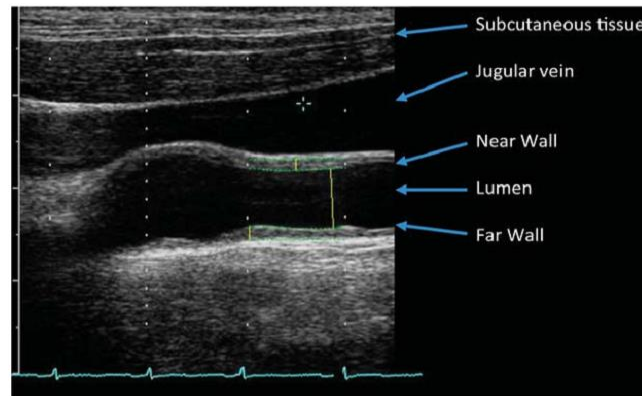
Image of CIMT Ultrasound scan in the distal 1 cm of the CCA. (O’Leary & Bots, 2010)
